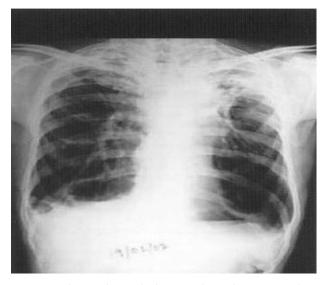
Cheat radiograph done on the 10th post-procedure day showing reduction in size of the treated bulla.
